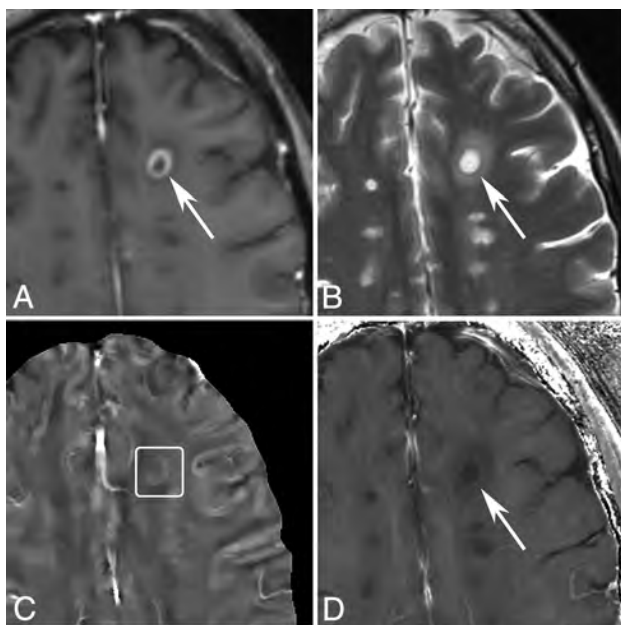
MR images of a shell-enhancing lesion in a 51-year-old man with MS. A, T1WI + Gd. B, T2WI. C, QSM. D, R2*. A shell-enhancing lesion (arrows) is found on the T1WI + Gd and appears slightly QSM hyperintense (C, box).
